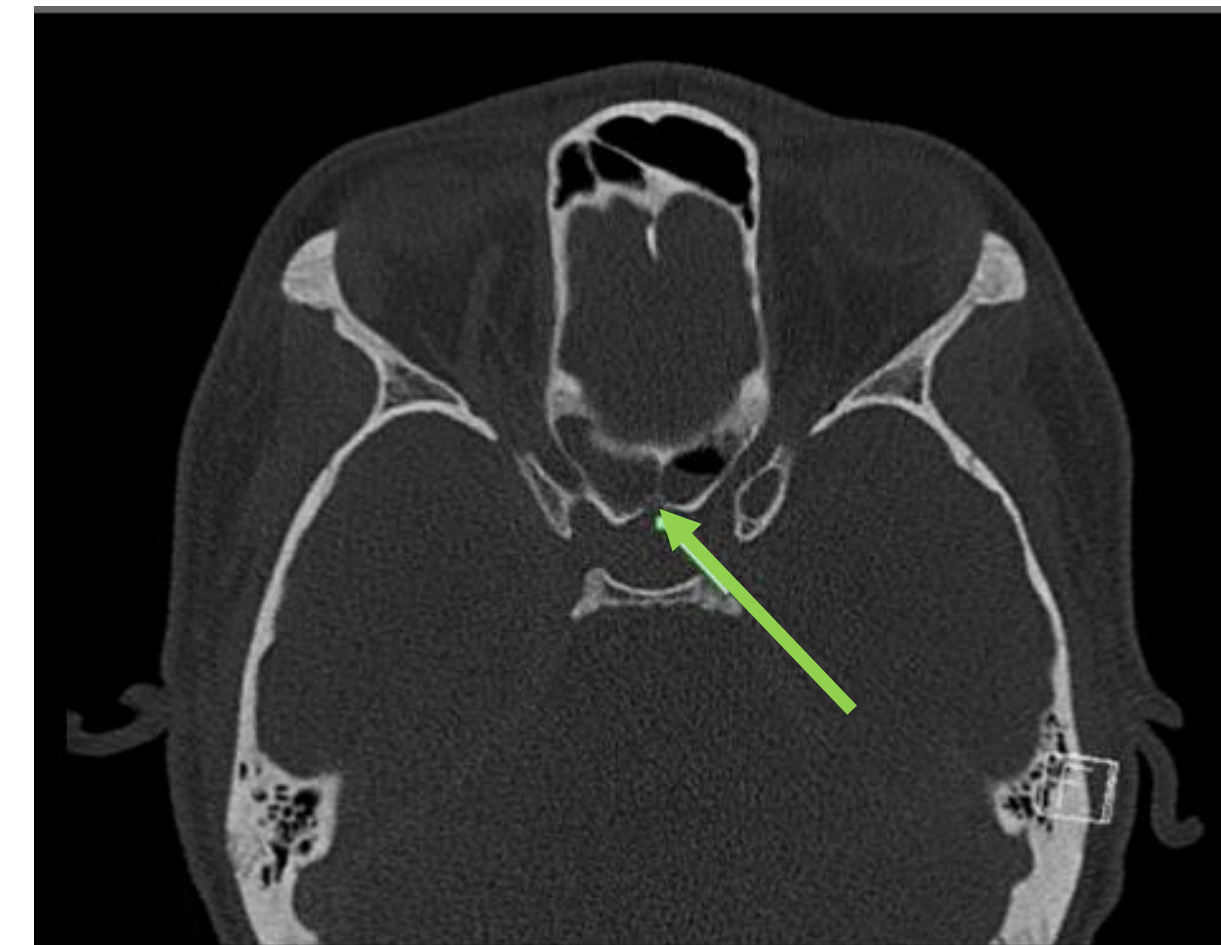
CT Sinus with contrast, axial cut, ethmoid and sphenoid sinus disease with bony dehiscence along posterior wall of right sphenoid sinus/anterior sella (arrow)
